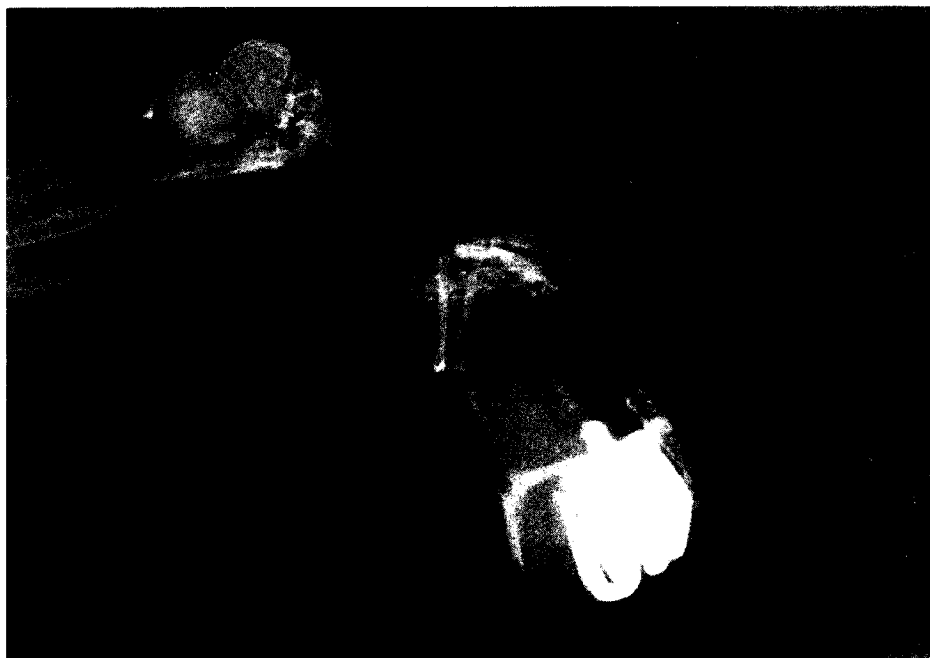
Lateral radiographic view of Micronesian kingfisher with abdominal distention after receiving barium sulfate.
